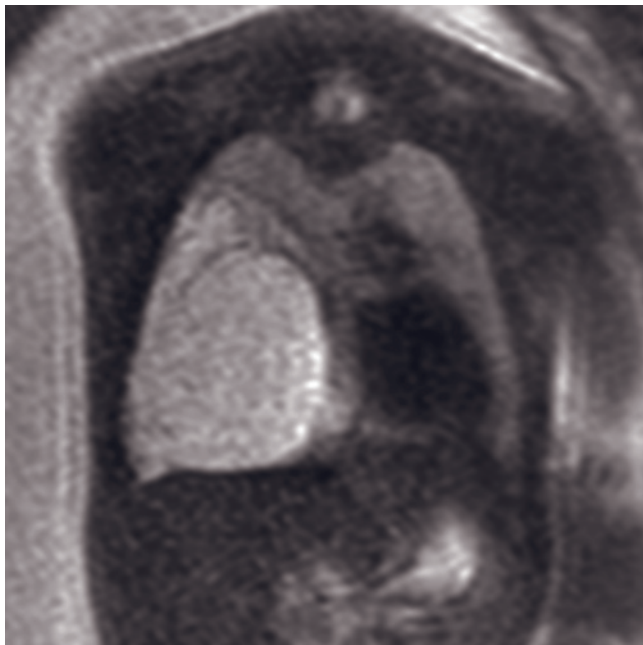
(*Continued*) fetus at 30 weeks of gestational age demonstrate herniation of stomach and bowel above the diaphragm, occupying the left side of the fetal chest. A small amount of liver is also seen within the left hemithorax. Slightly oblique coronal T1-weighted GRE image (e) in a third patient at 28 weeks of gestation demonstrates bowel within the left fetal hemithorax as evidenced by the hyperintense meconium in the distal bowel lumen.
